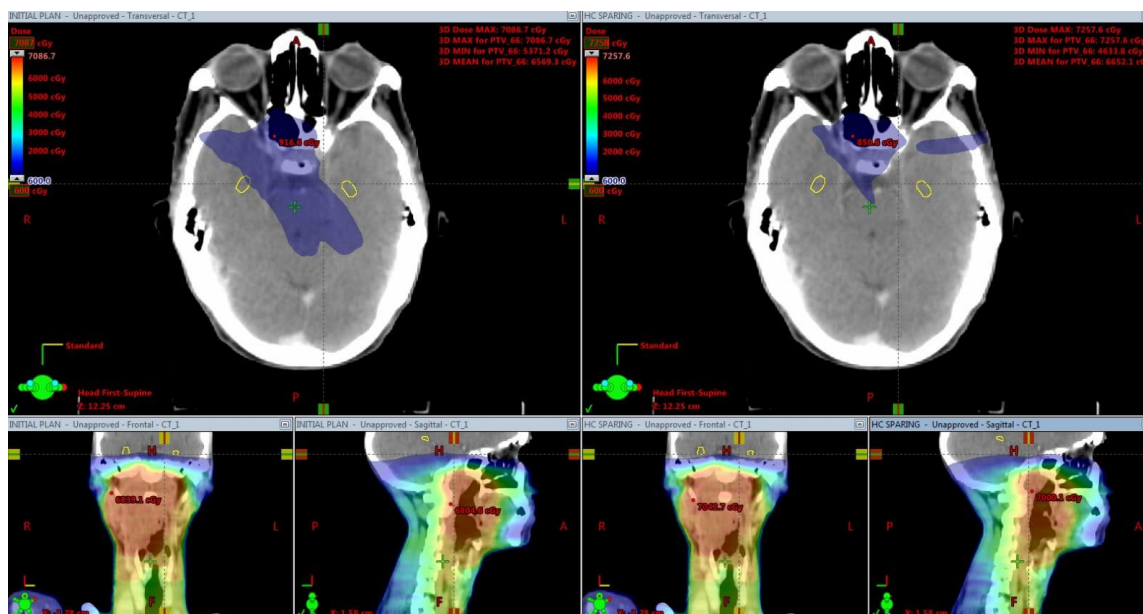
Representative treatment-planning system screenshots comparing the Initial Plan (non-hippocampus-sparing, left) and the HC Sparing (hippocampus-sparing, right) VMAT plans for a representative patient. Top row: transversal CT slices with color-wash dose distribution showing the high-risk PTV (PTV_66, blue-purple wash) relative to the bilaterally contoured hippocampi (yellow contours); reported 3D maximum, minimum, and mean doses to PTV_66 were comparable between the Initial Plan (7086.7/5371.2/6569.3 cGy) and HC Sparing plan (7257.6/4633.8/6652.1 cGy). Bottom row: frontal and sagittal reconstructions confirming maintained target coverage across both plans.
